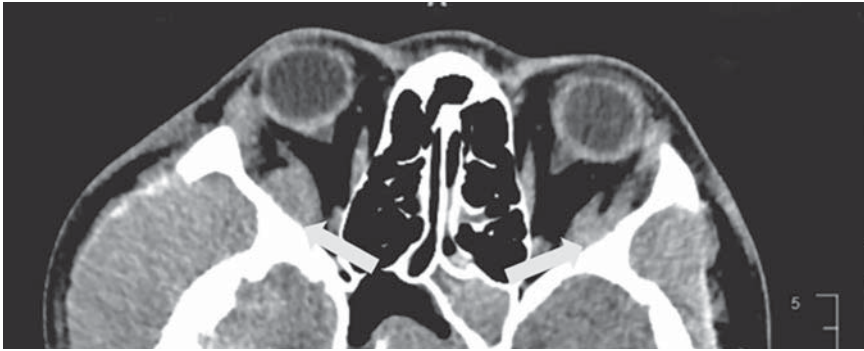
Computed tomography scan showing hyperdense lesion at bilateral extraconal spaces causing displacement and stretching of lateral recti muscles.
